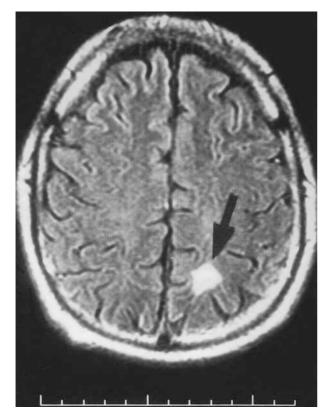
MRI scan showing the presence of a high signal lesion (black arrow), suggestive of an ischaemic area, in the left high parietal lobe.
